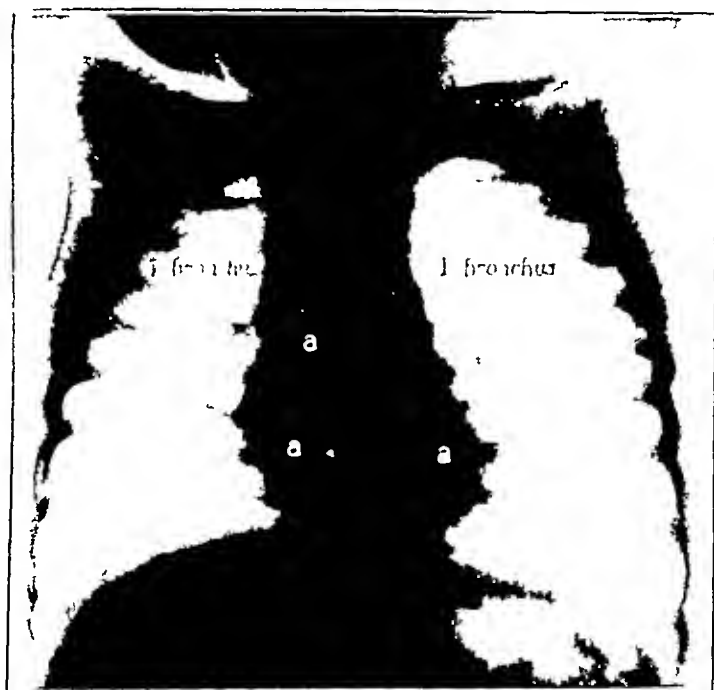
(case 5)—Roentgenogram showing collapse of the right lung, particularly the upper lobe, right main bronchus at almost right angle, abscessed nodes (*a, a, a*) in inferior tracheobronchial space.
